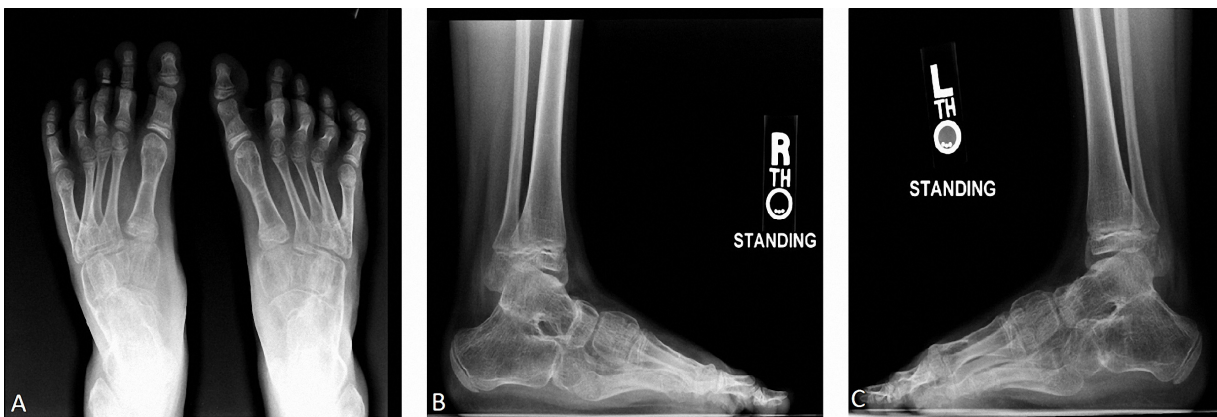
Postoperative standing radiographs of feet: (A) Antero-posterior view. (B) Lateral right foot. (C) Lateral left foot.
